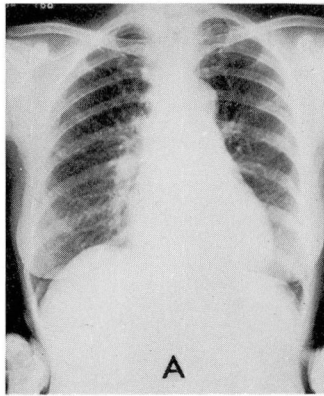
Roentgenograms two months postoperatively. The transverse cardiac diameter was 13.6 cm.
